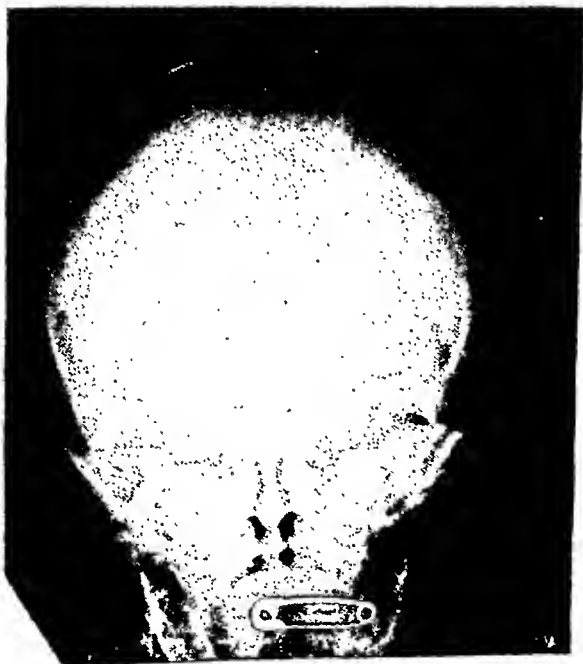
X-ray of skull on discharge from the hospital on Nov. 29, 1939, showing normal sutures.
